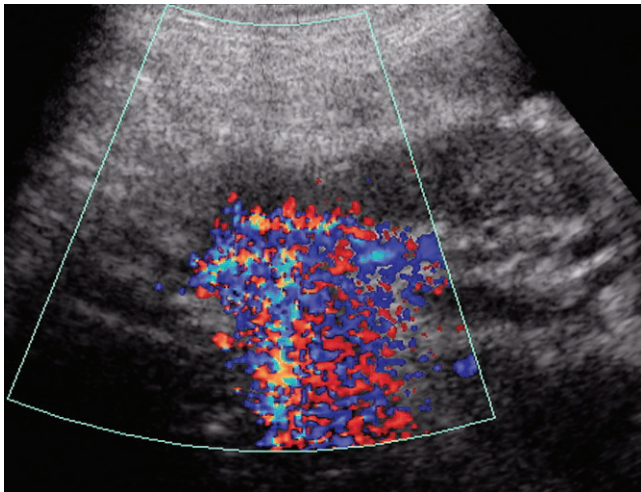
The longitudinal color Doppler image shows perivascular tissue vibration in the upper hilar region of the right kidney.
